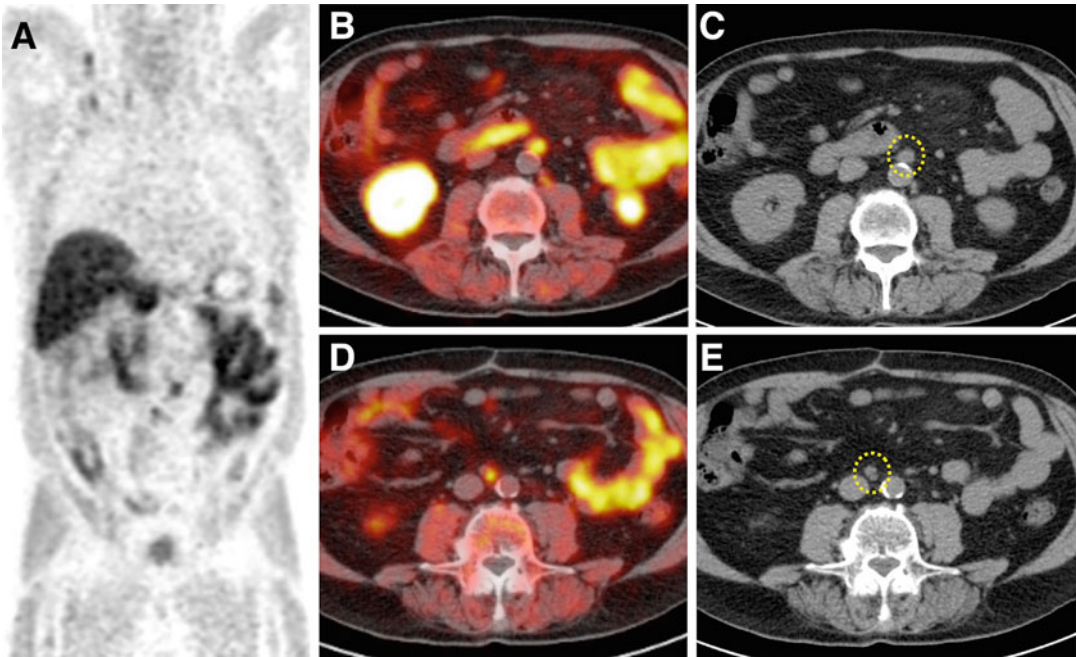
Coronal PET displayed with maximum intensity projection (a) showing focal uptake of ^{18}F -fluorocholine in the *middle* areas of the abdomen in a prostate cancer patient with high risk of regional lymph node involvement. On fused PET/CT and CT, two radiotracer avid lymph nodes
